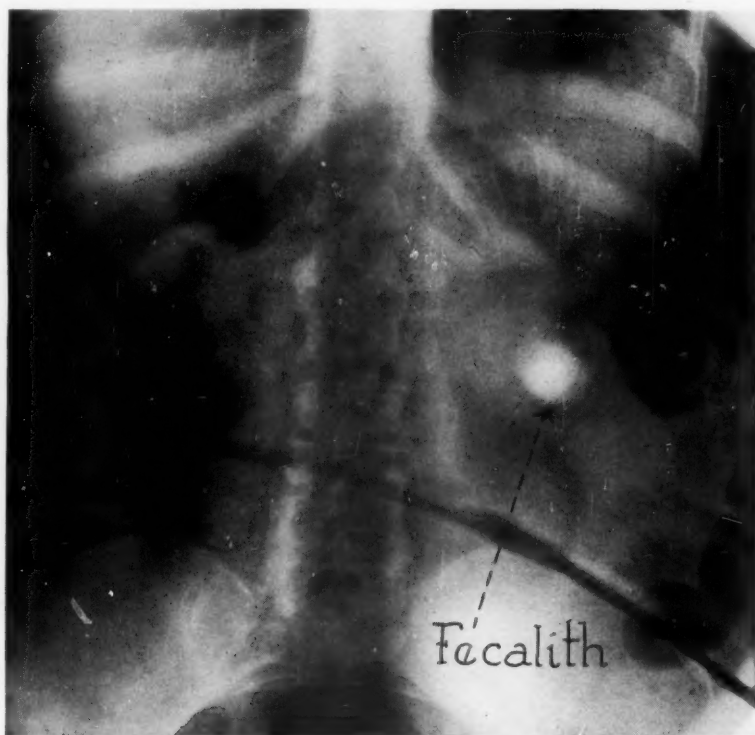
Roentgenogram showing fecalith and distended loops of small bowel in which valvulae conniventes are distinctly outlined.
